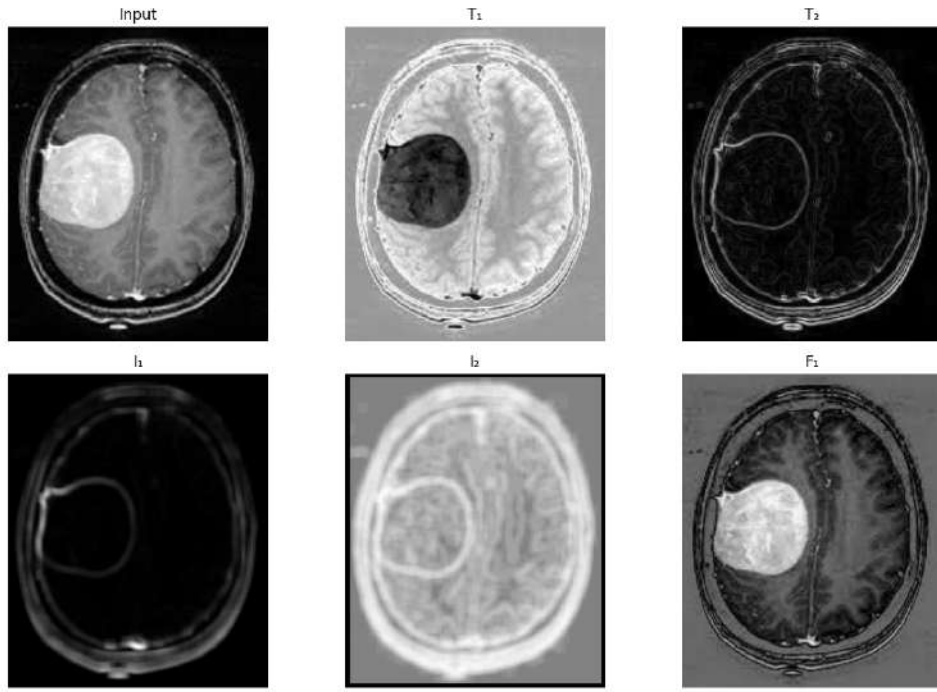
Transformation of a Noisy MRI Image into NRS Components(T_1, T_2, I_1, I_2, F_1)
